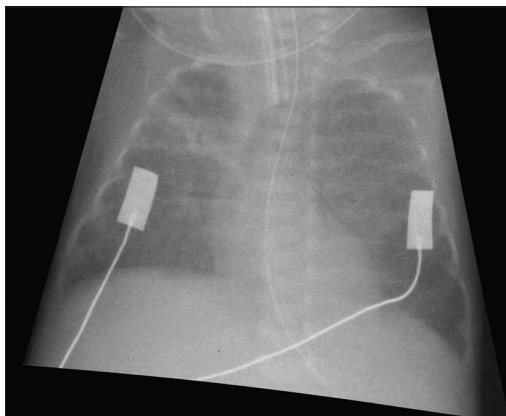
Chest radiograph of preterm infant (born at 23 weeks' gestation) on the first day of postnatal life showing typical appearances of respiratory distress syndrome (uniform ground glass appearance of both lung fields).
